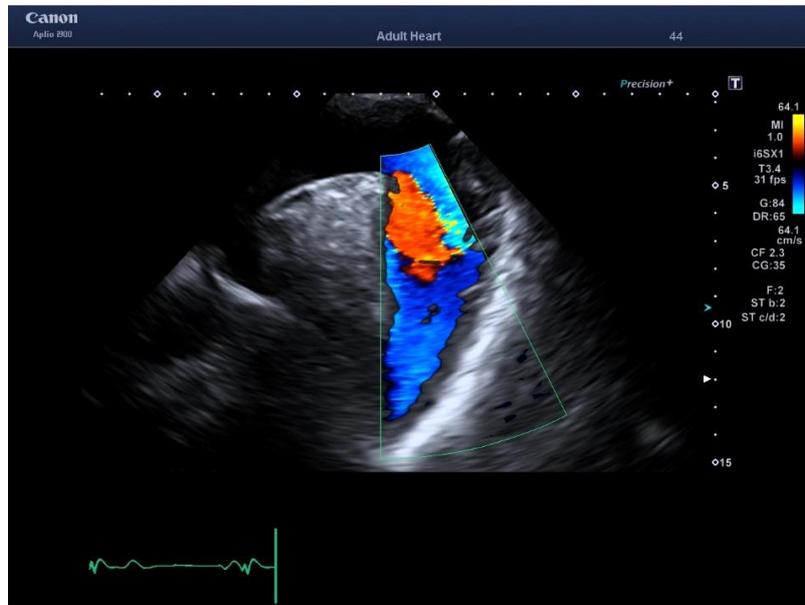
Colour Doppler demonstrating retrograde flow in the false lumen of a descending aortic dissection
